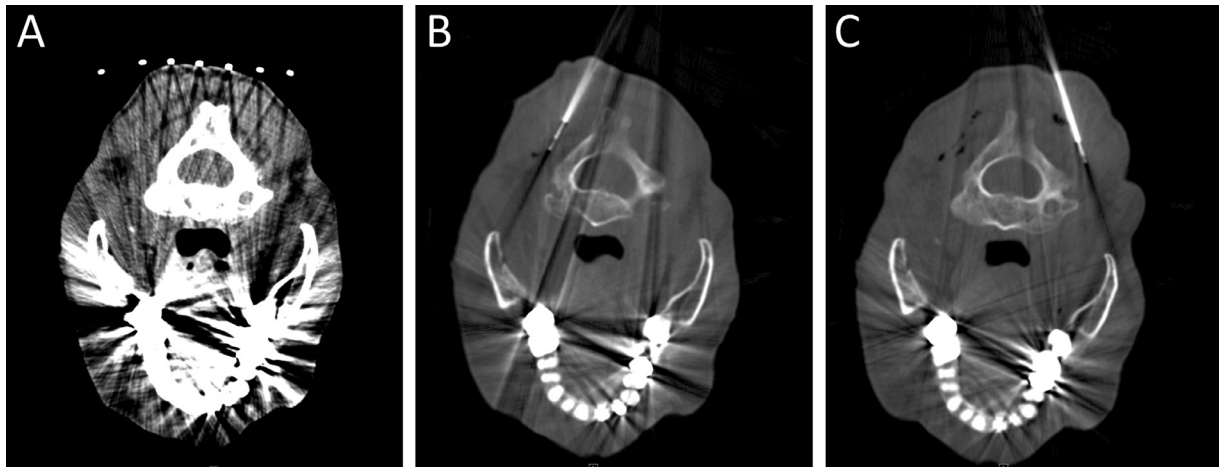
Procedural images from CT guided nerve block. (A) Planning axial images at the level of the posterior elements of C2. The target injection sites (white arrows) are the fat planes between the inferior oblique and semispinalis. (B) Images showing needle placement at the target site followed by (C) images after injection of a small amount of dilute contrast showing infiltration along the fat plane. (D) Post-procedure images showing spread of injectate and contrast along the fat plane
